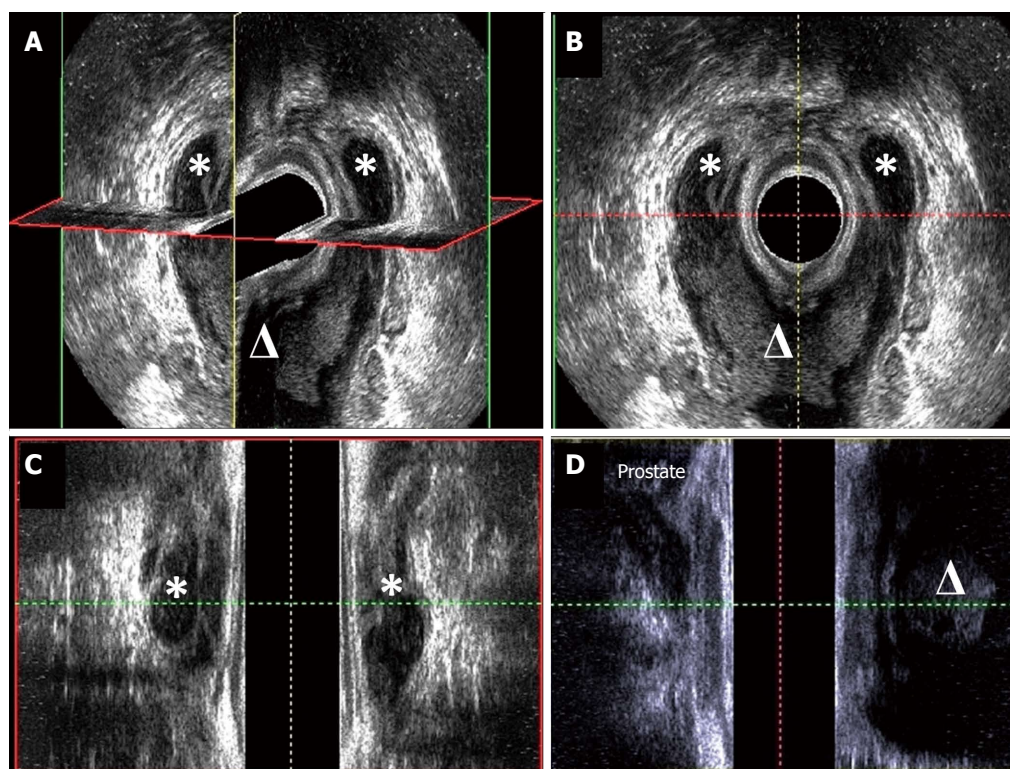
Three-dimensional endoanal ultrasonography of horseshoe abscess (A), cross-sectional view (B), coronal view (C) and sagittal view (D). The asterisk means abscess in ischiorectal space and the triangle means abscess in deep postanal space.
